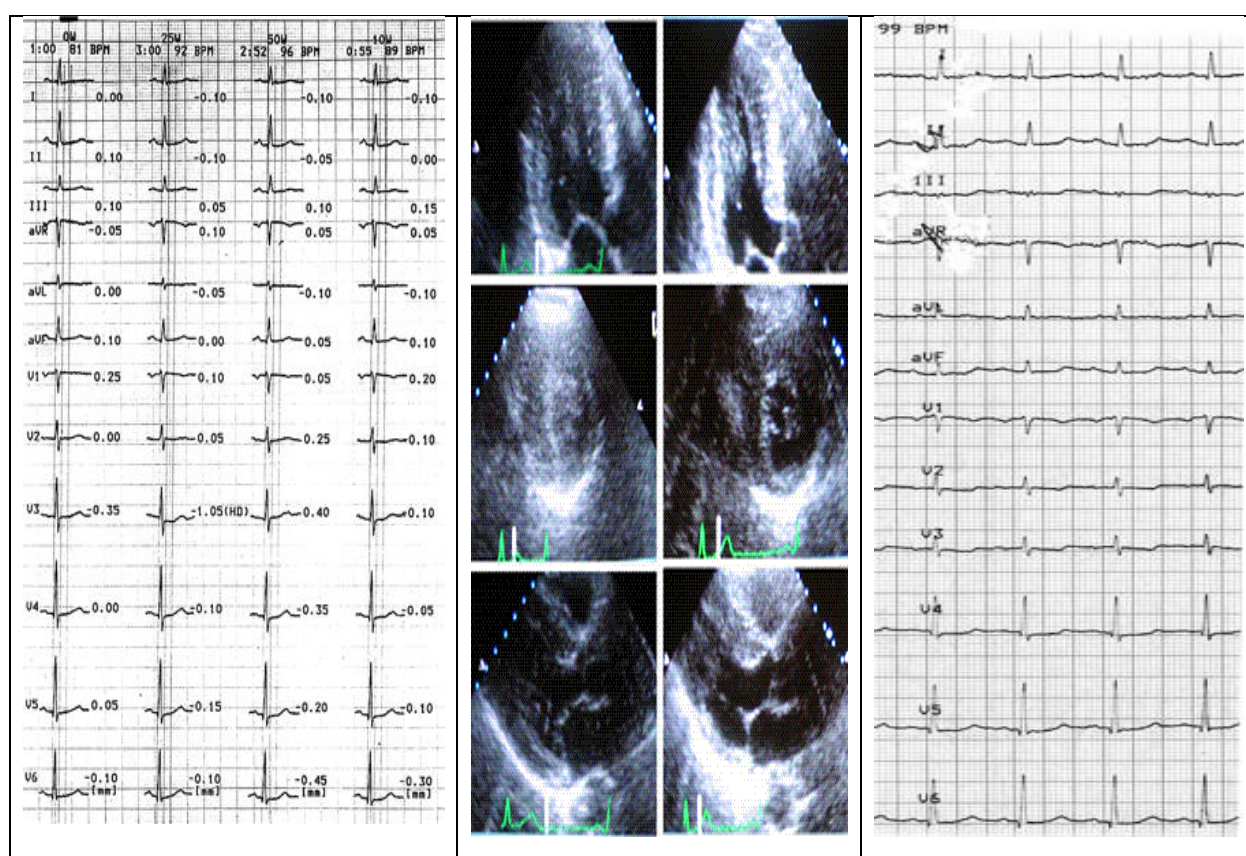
A clinical pattern of false-negative ExoCG results in a patient with typical Angina. During stress echocardiography against the background of the highest level
